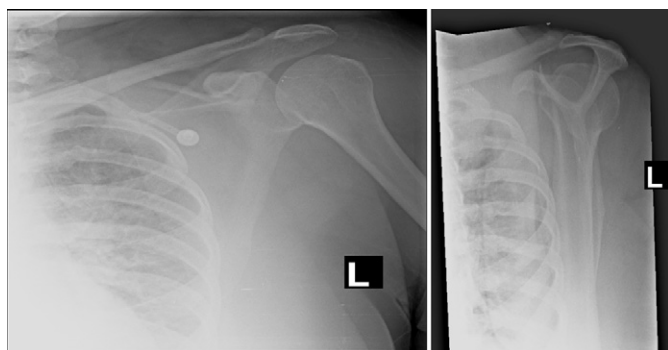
showing X-ray of left shoulder.
